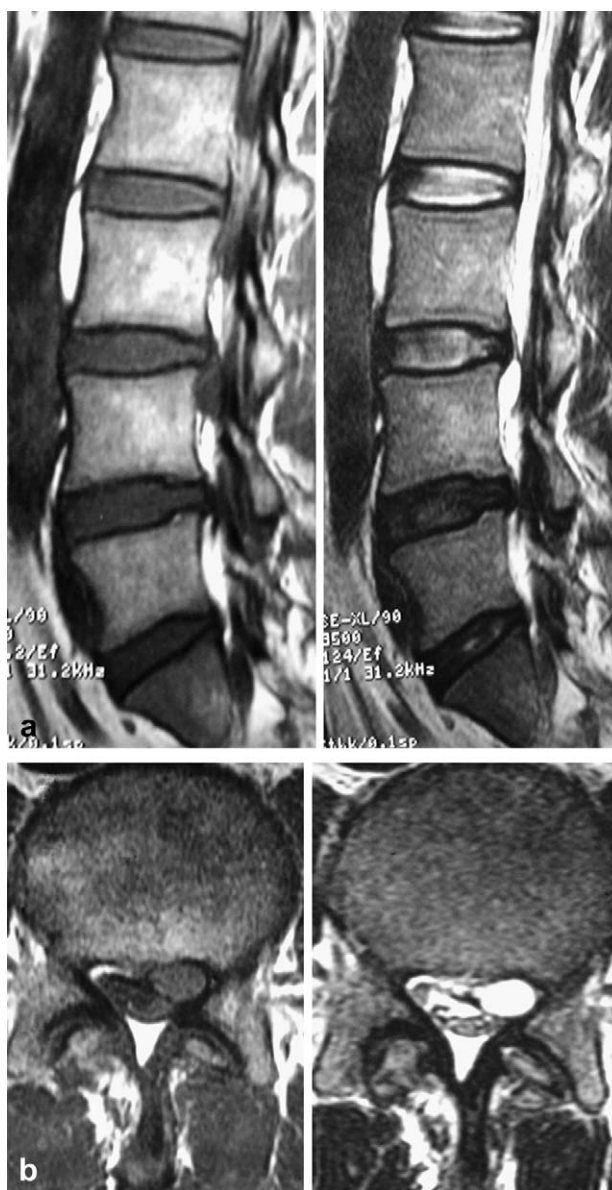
Sagittal (a) and axial (b) projections of magnetic resonance T1-weighted (left sides) and T2-weighted (right sides) images showed compression of the dural sac at L3–L4 by a lesion with uniform high signal intensity on the T2-weighted images. The initial impression was down-migrated disc fragments that had undergone cystic liquefaction.
